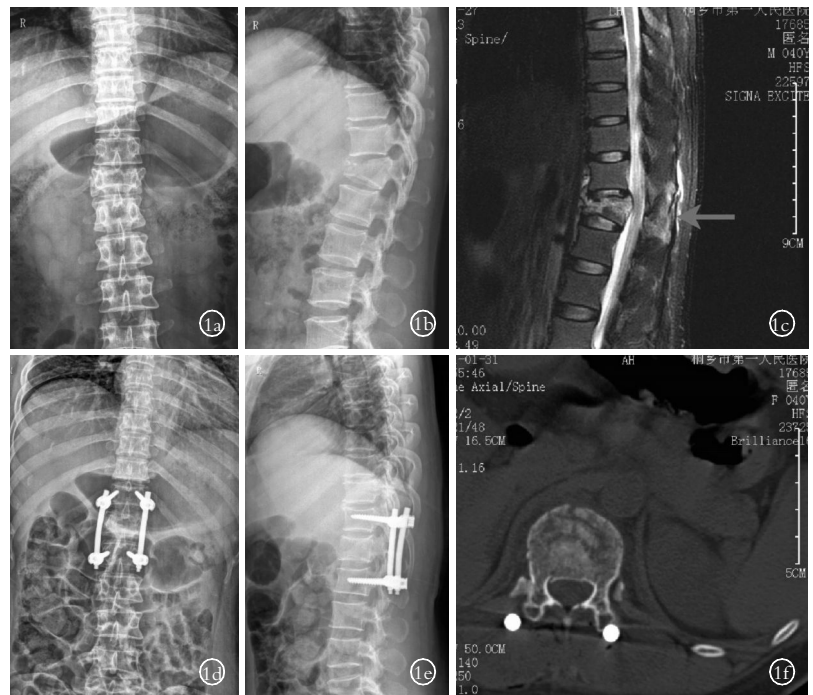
男性患者,28 岁,重物压伤致腰背疼痛伴活动受限,Denis 分型 B 型,ASIA 分级 E 级 1a,1b.术前腰椎正侧位 X 线片示 L₁ 骨折,后凸畸形 1c.术前 MRI 示 L₁ 水平脊髓受压,后方韧带复合体断裂 1d,1e.术后腰椎正侧位 X 线片示骨折复位良好,后路短节段固定,内固定在位良好 1f.术后 1 年 CT 复查骨折愈合良好,椎管无明显占位
